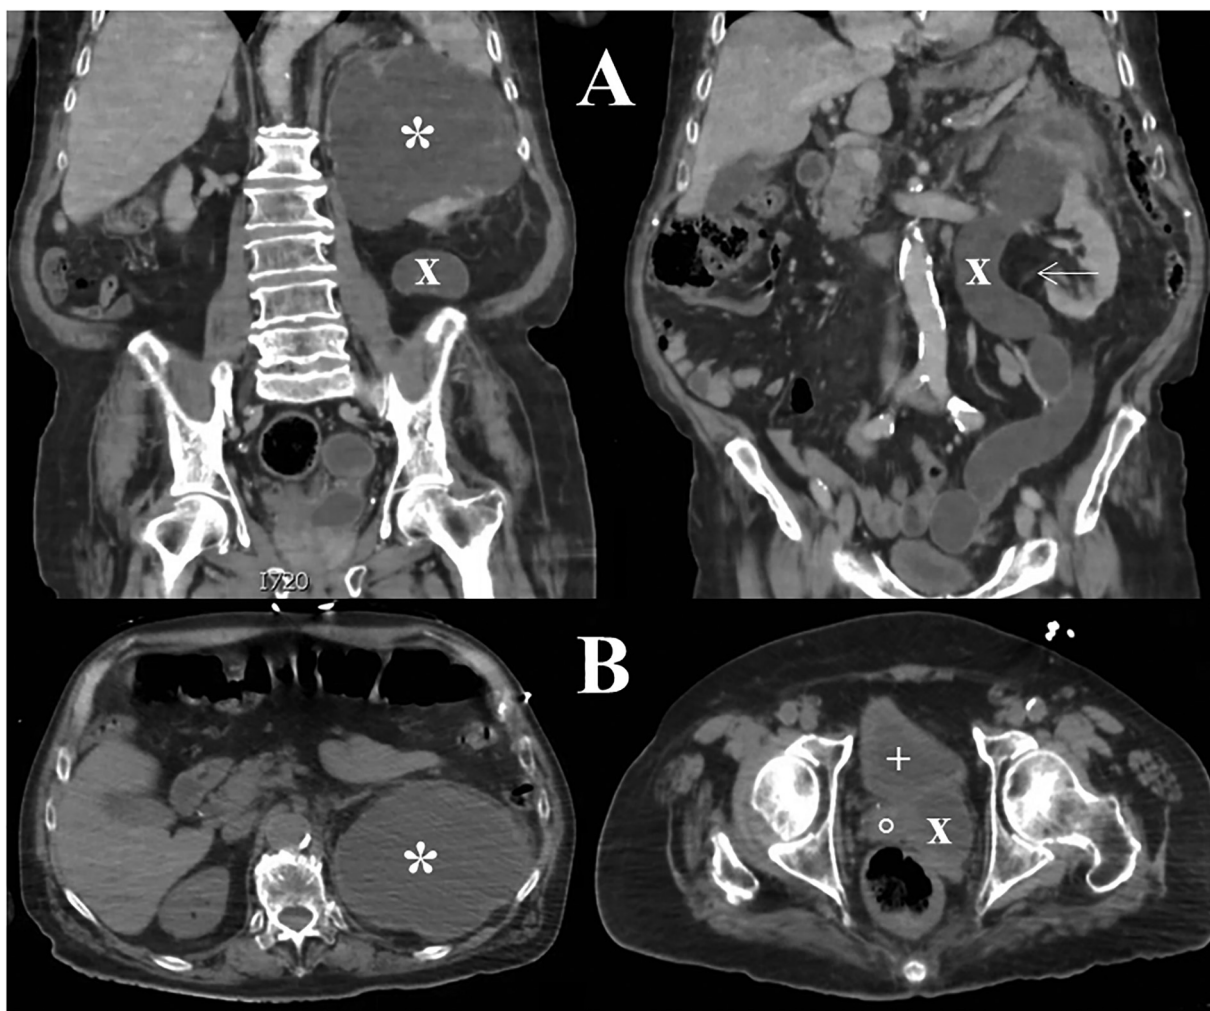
CT Abdomen and Pelvis without Contrast. (A): Coronal view. (B): Axial view.
